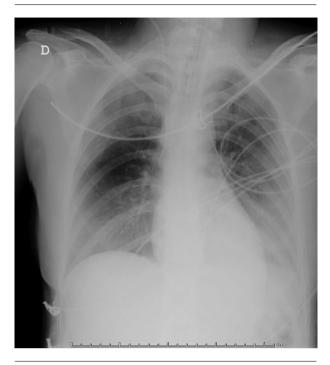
Chest X-ray showing diffuse increased opacity in both lung fields, suggesting pulmonary edema
